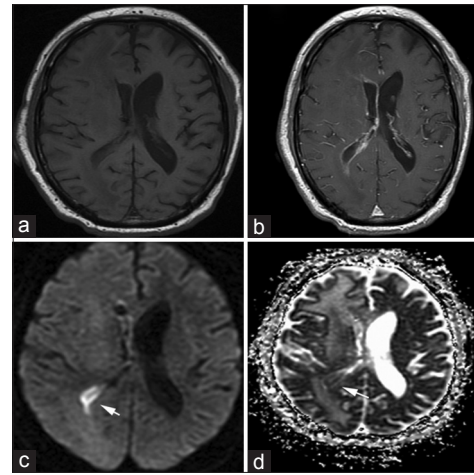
Magnetic resonance image of the brain shows T1 without contrast, (a) T1 with contrast, (b) diffusion-weighted imaging sequence, (c) apparent diffusion coefficient sequence, and (d) magnetic resonance image reveals ventricular wall enhancement with bright diffusion-weighted imaging signals and dark apparent diffusion coefficient signals, indicating the presence of intraventricular purulence materials from the ruptured abscess denoted by the arrows
